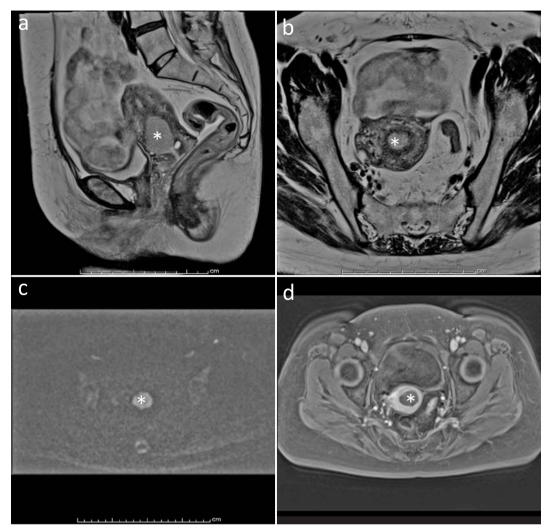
A 33-year-old woman diagnosed with pT1b carcinoma (1.5 T MR images) a. T2-weighted sagittal image, b. T2-weighted axial image, c. Diffusion-weighted axial image, d. Dynamic contrast images with 1.5 T MRI.
